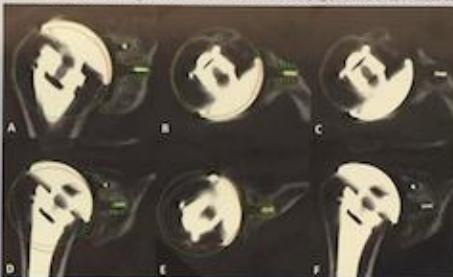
Digital tomograms of the position of the glenoid and humeral component on the preoperative CT (A), postoperative CT (B), and minimum 2-year follow-up CT (CT3) in 3 patients (A-C, D-E, and F-G). Panel A shows increased glenoid inclination and retroversion, while panel D shows increased glenoid inclination and anteverision. Panels B and E show central anchor peg osteolysis (Grade 1) and bone integration around the central anchor peg (Grade 2 or 3). In these cases, the glenoid component has shifted into increased retroversion (B) or increased anteverision (E). However, the central anchor peg has shifted into increased anteverision (D) and bone integration around the central anchor peg (Grade 2 or 3) is even seen on the 2 year follow-up CT after the digital tomograms are removed (F).
